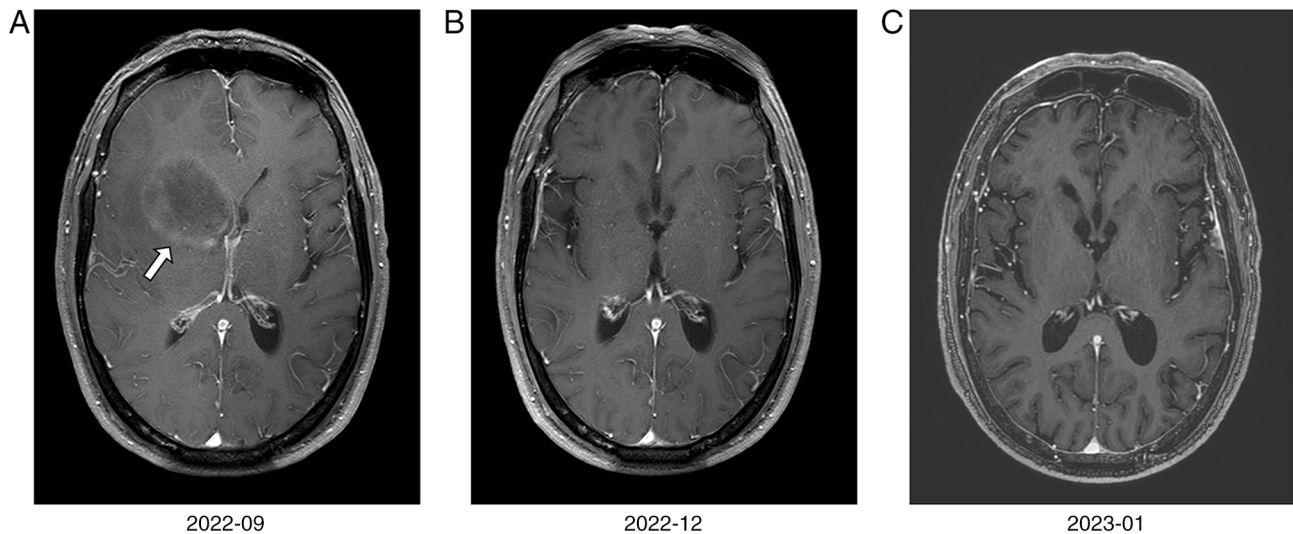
Serial brain MRI of the right frontotemporal parenchymal metastasis. (A) Axial T1-weighted post-contrast image from September 2022 demonstrating a heterogeneously enhancing mass in the right frontotemporal lobe (white arrowhead). (B) Follow-up MRI 2 months after resection (December 2022) showing the resection cavity with no evidence of local recurrence. (C) MRI after the onset of ocular symptoms (January 2023) confirming continued local control at the primary resection site. MRI, magnetic resonance imaging.
